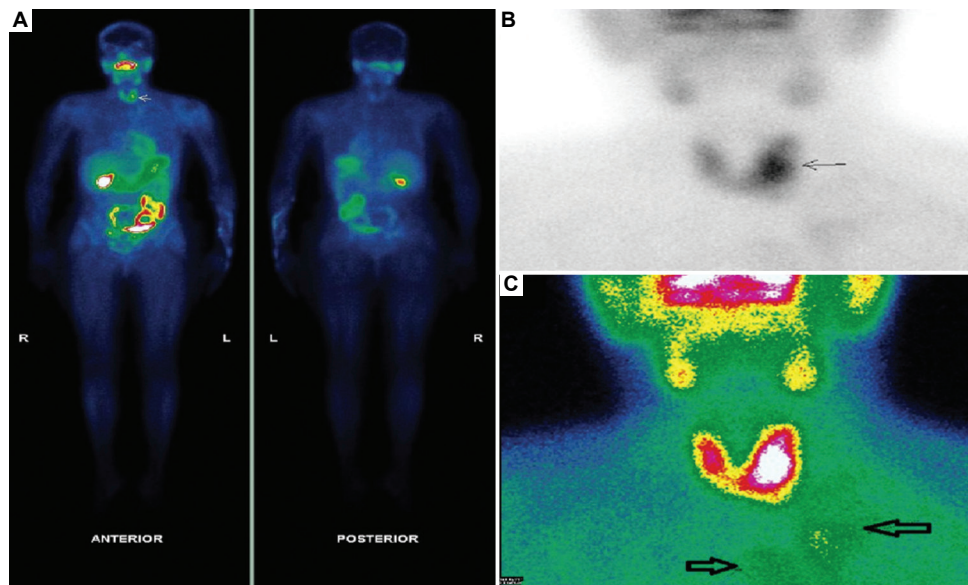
^{99m}Tc -MIBI whole-body scan, parathyroid scintigraphy, and cervical static acquisition show physiological uptake, a pathologic focus in the left mediolobar region, and low uptake near the clavicle and manubrium, respectively, suggestive of brown tumors. (A) Whole-body scan with ^{99m}Tc -MIBI show no definite suspicious focus suggestive of brown tumors, except for physiological radiopharmaceutical uptake in the parotid, submaxillary, hepatobiliary, and digestive regions. (B) Parathyroid scintigraphy showing a pathologic retention focus of ^{99m}Tc -MIBI in the left mediolobar region consistent with the retrothyroid nodule visualized on cervical ultrasound (indicated by the arrow). (C) Anterior cervical static acquisition following whole-body scan showing two areas of very low and heterogeneous ^{99m}Tc -MIBI uptake adjacent to the inner third of the left clavicle and the sternal manubrium, presumably corresponding to brown tumors on PET/CT examination (indicated by the arrow).
